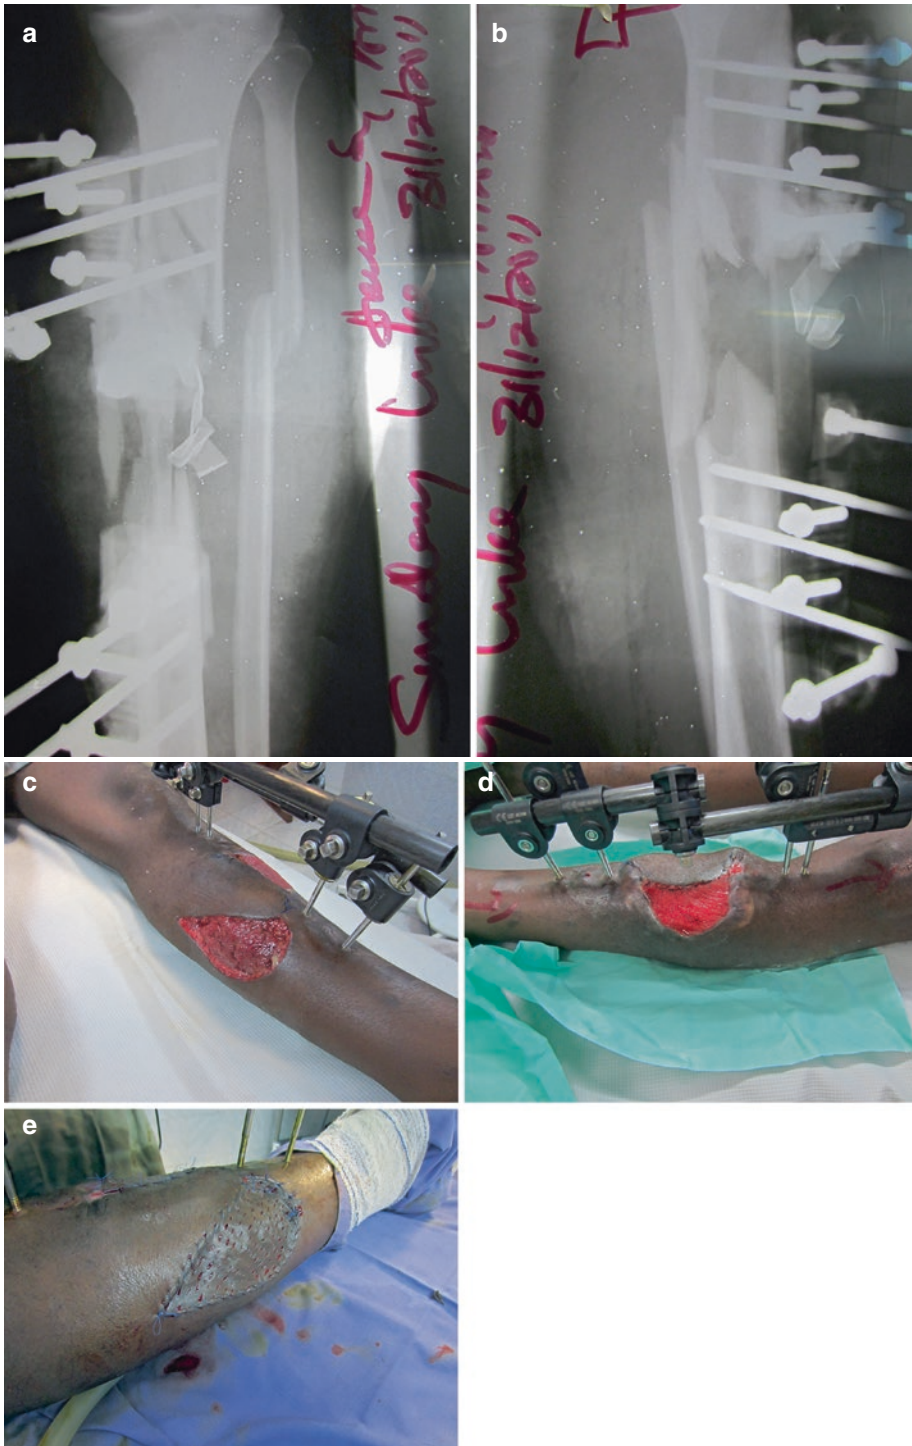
(a, b) X-rays of a comminuted Gustilo IIIB tib fib fracture with anterior bone loss. (c, d) A fasciocutaneous flap has been mobilized from the well-muscled lateral
